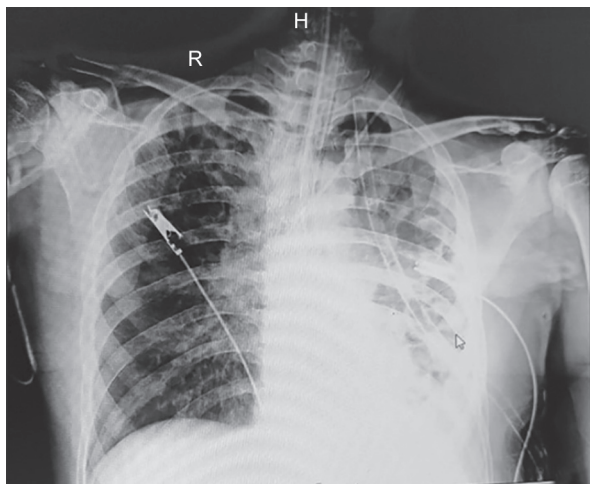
Chest X-Ray prior to ECMO- canulation
